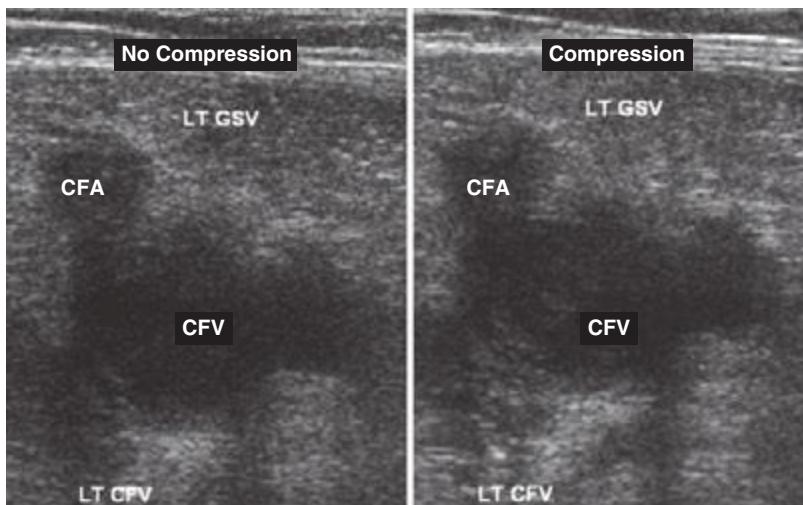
Venous ultrasound, with and without compression of the leg veins. CFA, common femoral artery; CFV, common femoral vein; GSV, great saphenous vein; LT, left.
